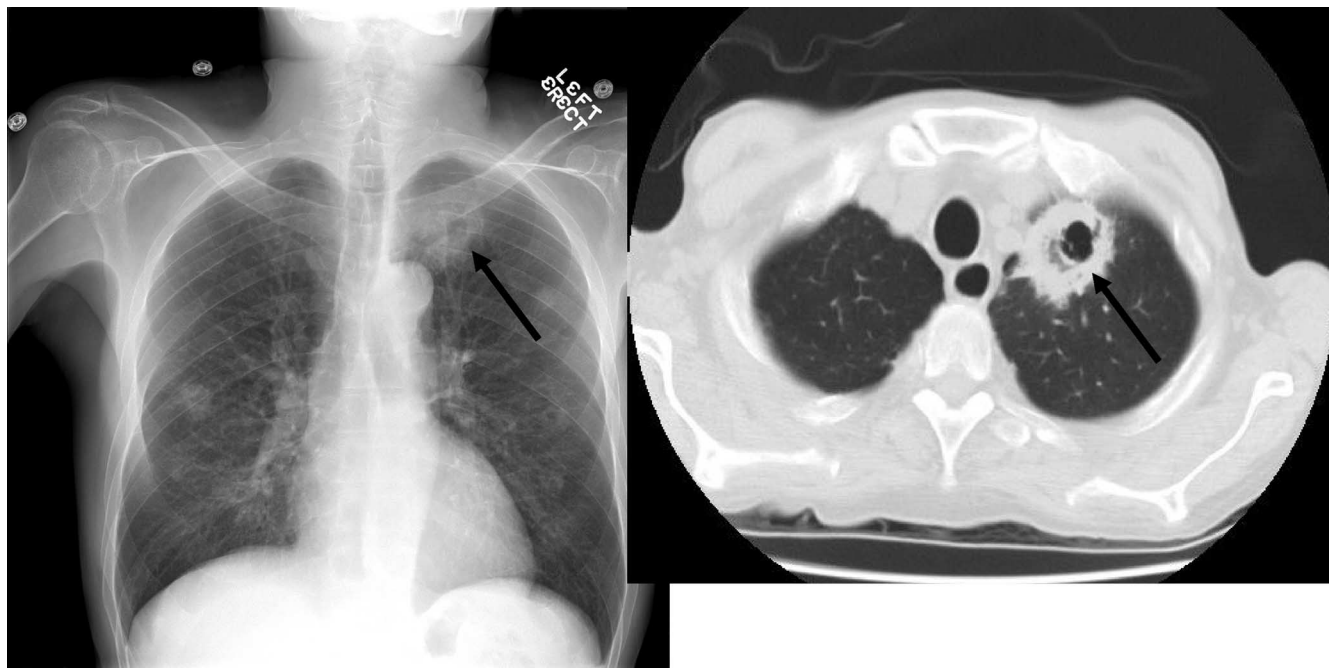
Invasive aspergillosis in a 52-year-old man with systemic lupus erythematosus who had been on chronic high-dose corticosteroids and azathioprine. The plain chest radiograph (left) is suggestive of septic pulmonary emboli, with multiple large nodules bilaterally, at least two of which contain central cavities. The right panel demonstrates one of these thick-walled cavities as seen by computed tomography. This patient also had *Aspergillus* in the brain, which is a common site of metastatic spread in immunocompromised hosts.
